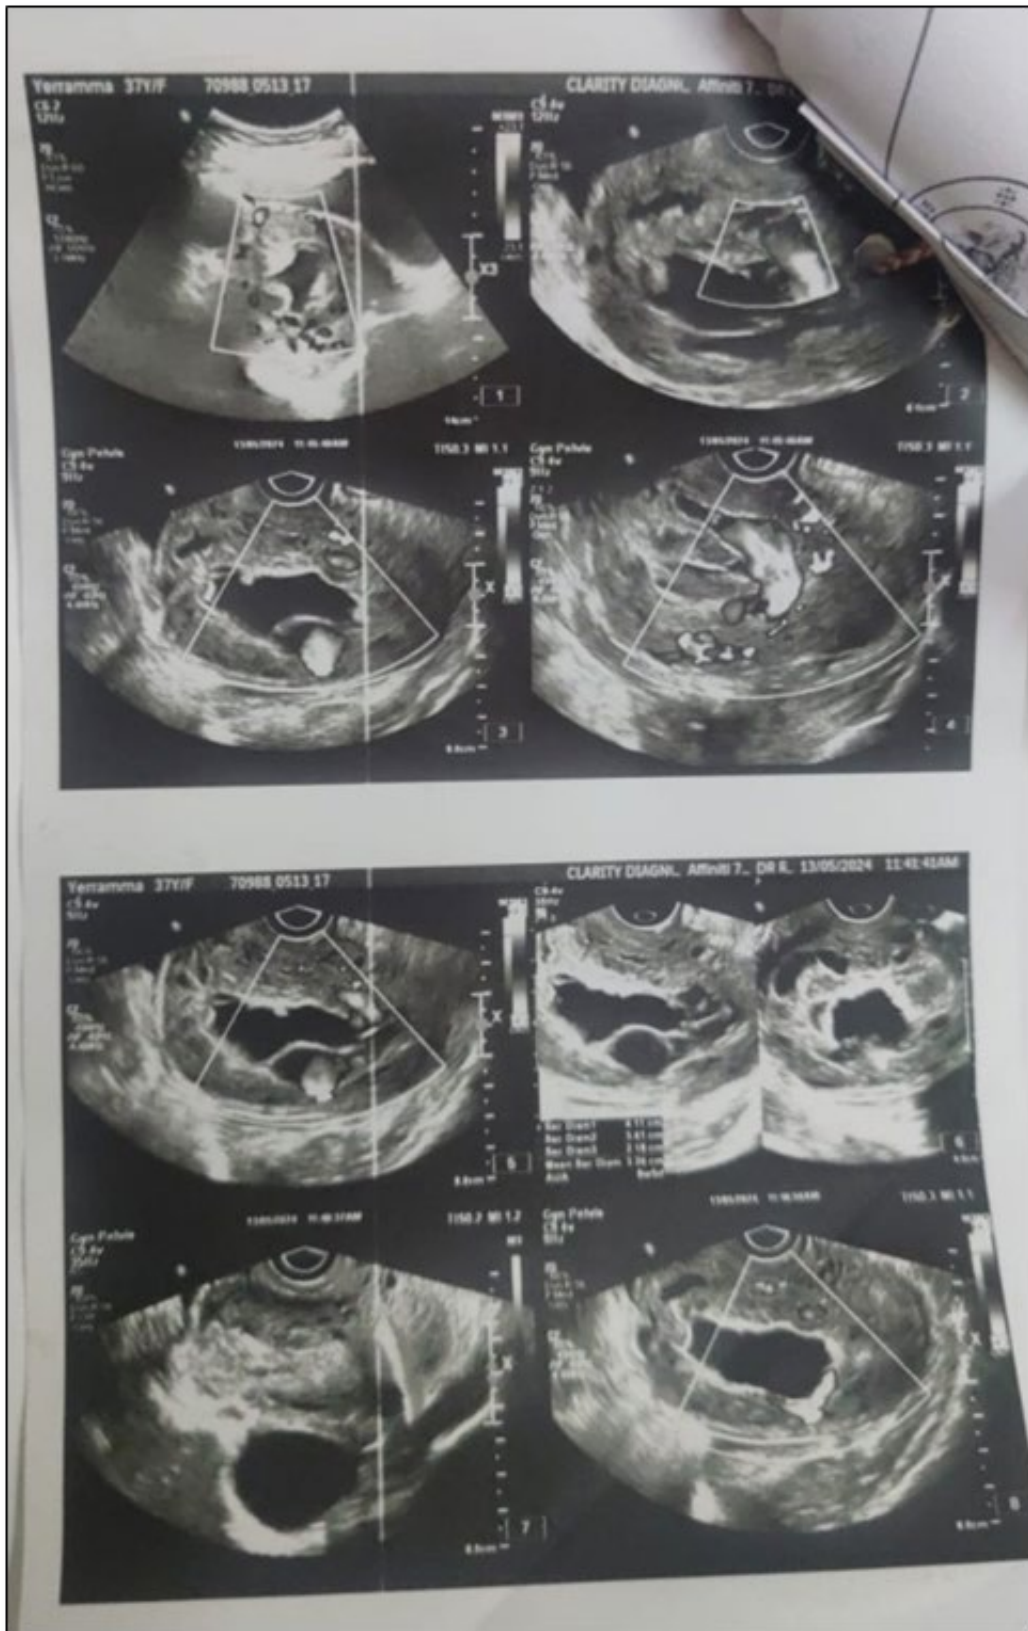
Shows Ultrasound for caesarian scar pregnancy.
